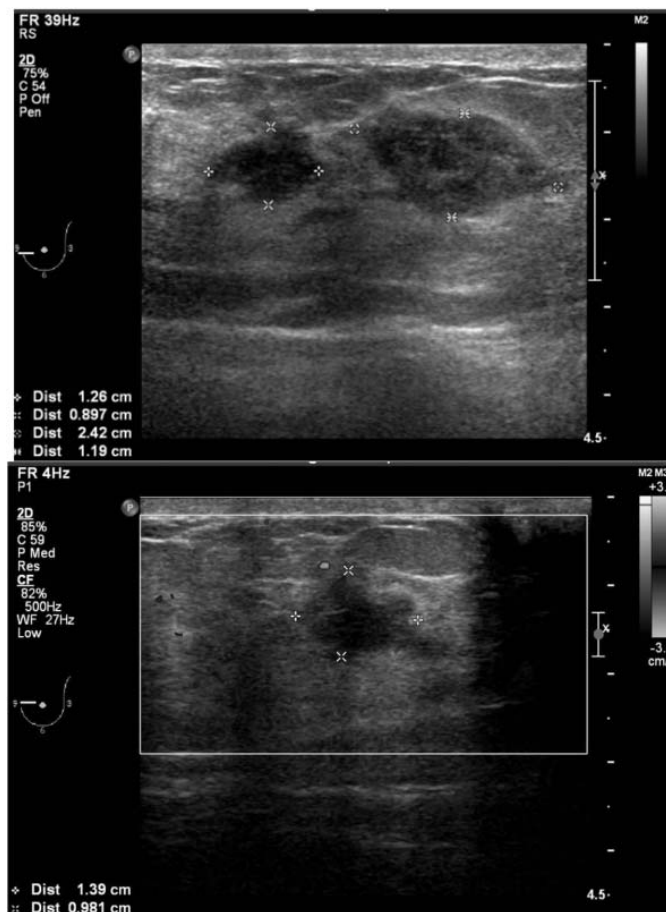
Ultrasound revealed three irregular hypoechoic/heterogeneous echogenic masses in the left lower inner quadrant.
